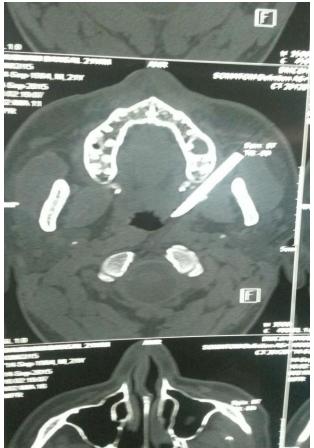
axial CT scan showing foreign body
